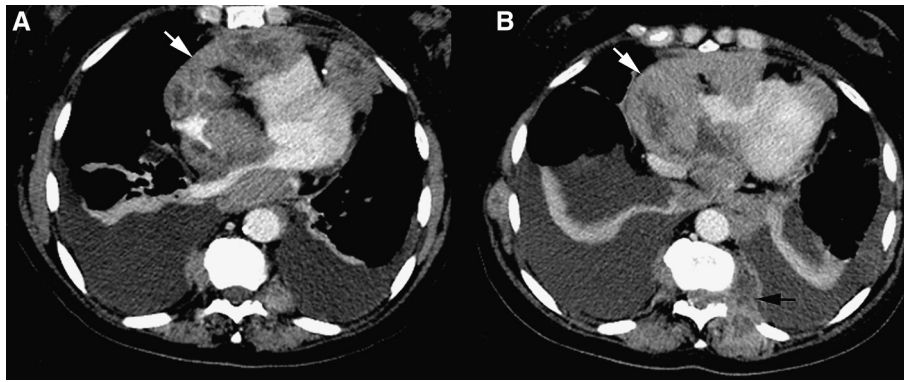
(A,B) Axial images from a contrast-enhanced computed tomography in a 65-year-old woman with recurrent acute myelogenous leukemia. There is a multilobular soft-tissue mass encasing the atria and the right ventricle, and at the left ventricular apex (white arrows), with severe compression of the left atrium and pulmonary veins. There also is mass-like thickening of the interatrial septum with enhancement and central necrosis. The normal myocardium of the heart in these regions is not seen nor is the pericardial fat plane; hence, invasion of the myocardium into the cardiac chambers is suspected. (B) In the paravertebral regions bilaterally, there are enhancing soft-tissue masses. The left paravertebral mass extends into the spinal cord and through the chest wall into the left erector spinae muscle (black arrow).
